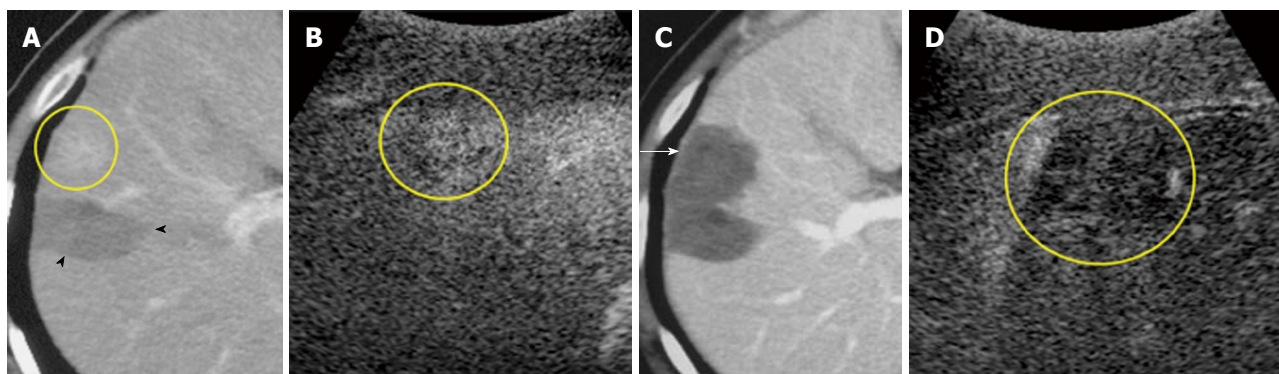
A 61-year-old man with 1.5-cm recurrent hepatocellular carcinoma after ablation therapy in segment 5 of the liver. A: Early-phase dynamic computed tomography (CT) scan shows recurrent tumor (circle). Non-enhanced area (arrowheads) was previously treated by radiofrequency ablation (RFA); B: Contrast harmonic ultrasound (US) using Levovist shows enhancement of viable focus of a hepatocellular carcinoma (HCC) nodule (circle); C: Portal-phase dynamic CT scan, which was obtained 3 d after RFA shows that the tumor was not enhanced, indicating complete necrosis of the lesion (arrow); D: Contrast harmonic US, which was obtained 3 d after ablation shows non-enhanced area (circle).
